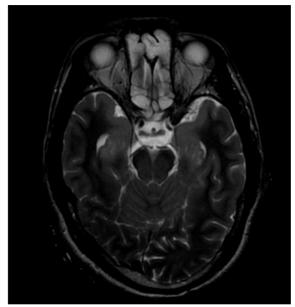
MRI scan case 1 (Bilateral medial temporal lobes and uncus hyperintensity)
